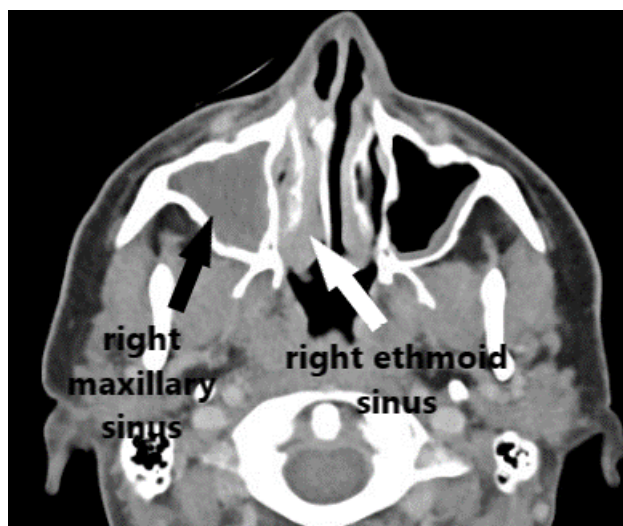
Computerized tomography (CT) of the facial bone with contrast (axial view) showing extensive sinusitis primarily involving the right frontal, ethmoid and maxillary sinus with possible antrochoanal polyp
